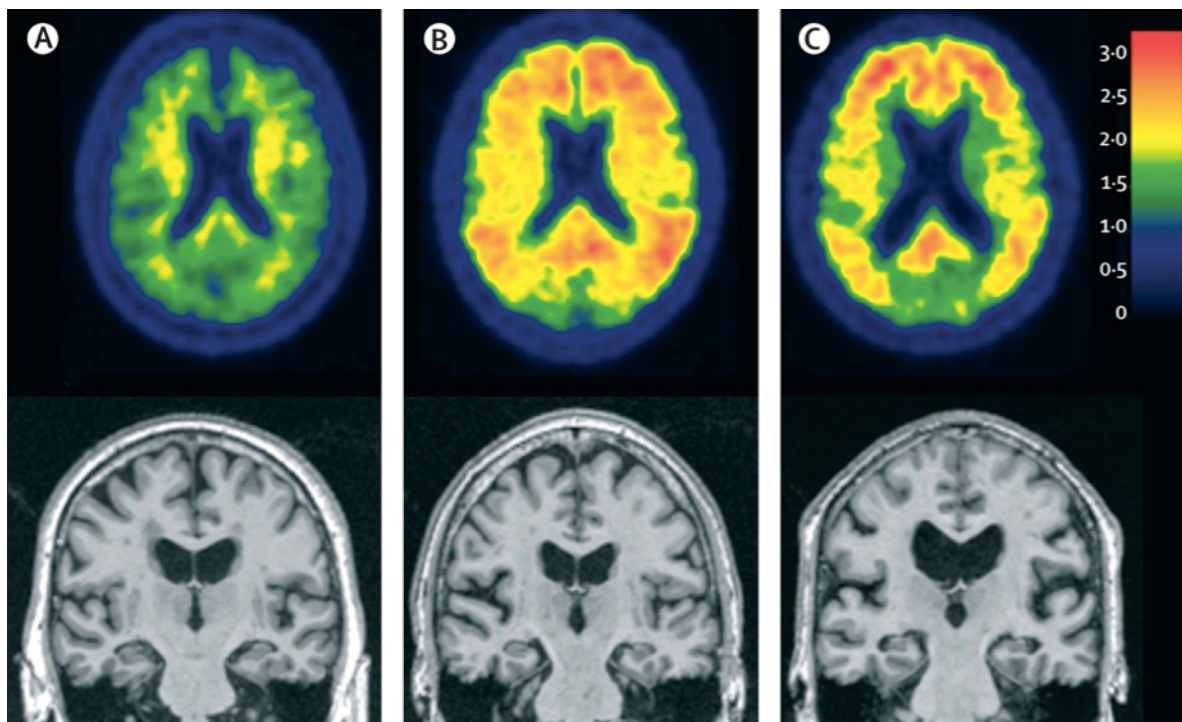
Axial PET amyloid imaging with Pittsburgh Compound B (PiB) (upper) and coronal structural MRI (lower) in three older patients. Regions of red and yellow indicate high Pittsburgh Compound B retention, indicating presence of amyloid deposition. (A) A cognitively normal individual with no evidence of A β on PET amyloid imaging with PiB and no evidence of atrophy on MRI. (B) A cognitively normal individual who has no evidence of neurodegenerative temporal atrophy on MRI, but has significant A β deposition on PET amyloid imaging. (C) An individual who has dementia and a clinical diagnosis of AD, a positive PET amyloid imaging study, and neurodegenerative atrophy of the temporal lobe on MRI.
